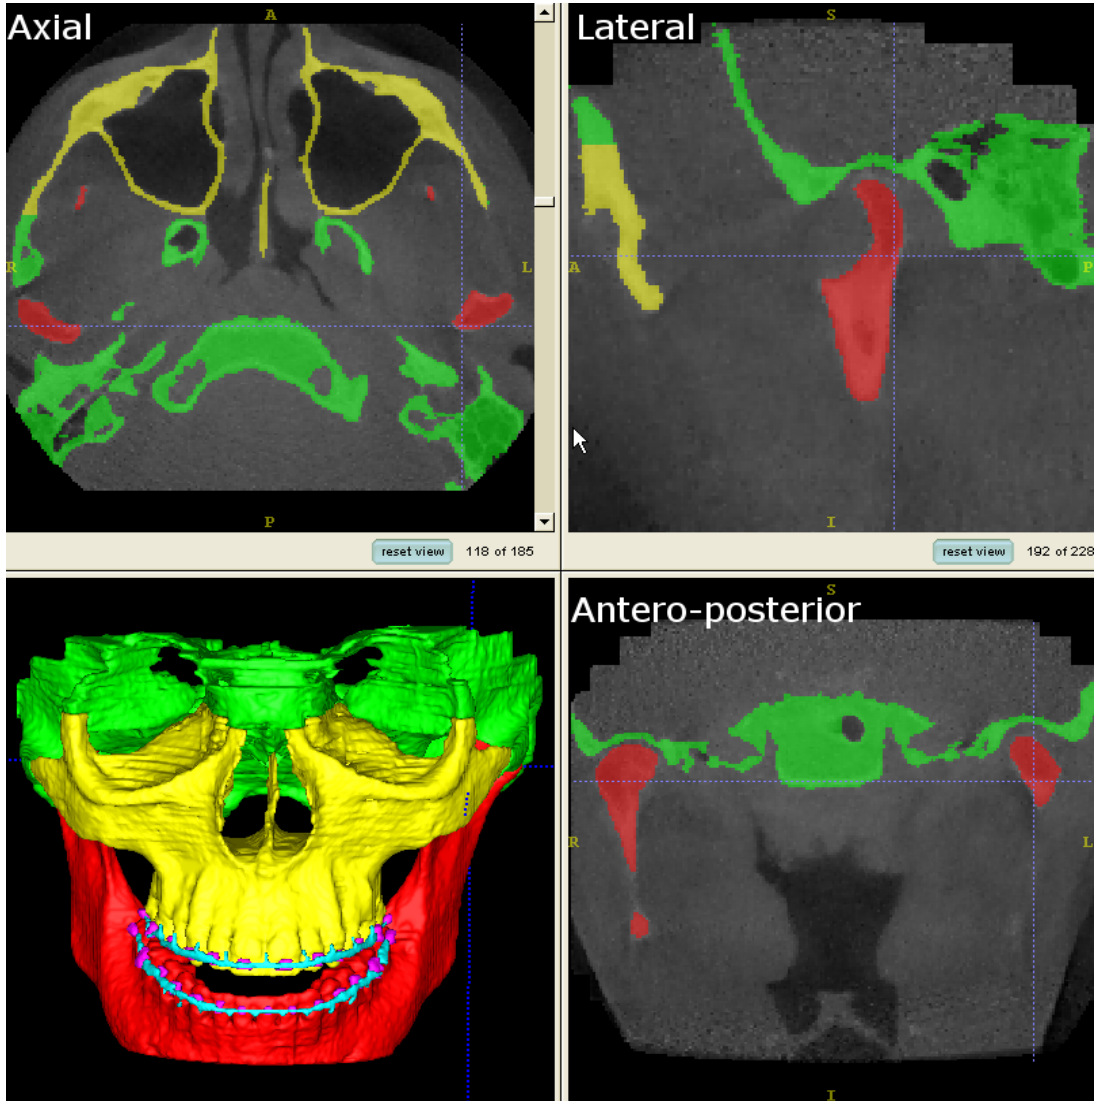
Three-dimensional cephalometry: Cephalometry can be performed on the three dimensional skeletal model formed from the CBCT. This allows the user to define landmarks, lines, planes, and measurements.
